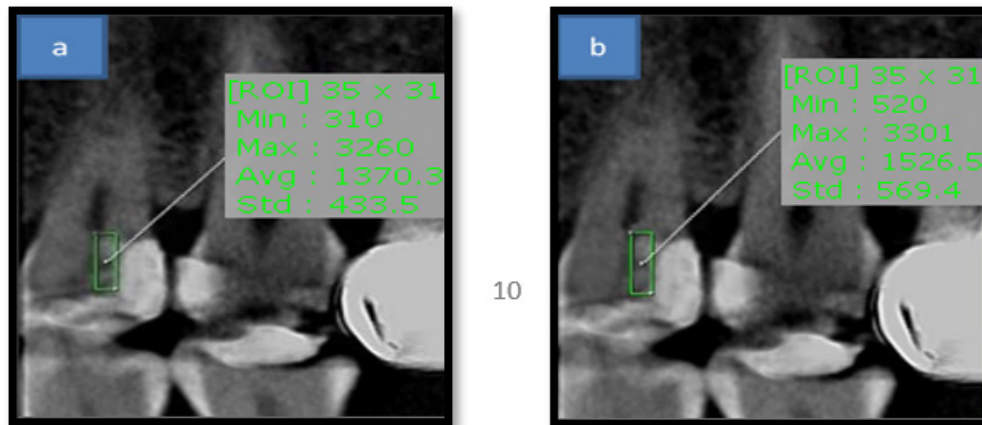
a) CBCT measurement of immediate post-operative remaining dentin density, b) CBCT measurement of Six months post-operative remaining dentin density
